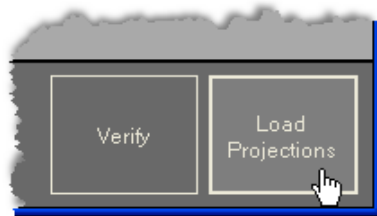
LungSPECT Chooser Dialog: Press the [Load Projections] button.
